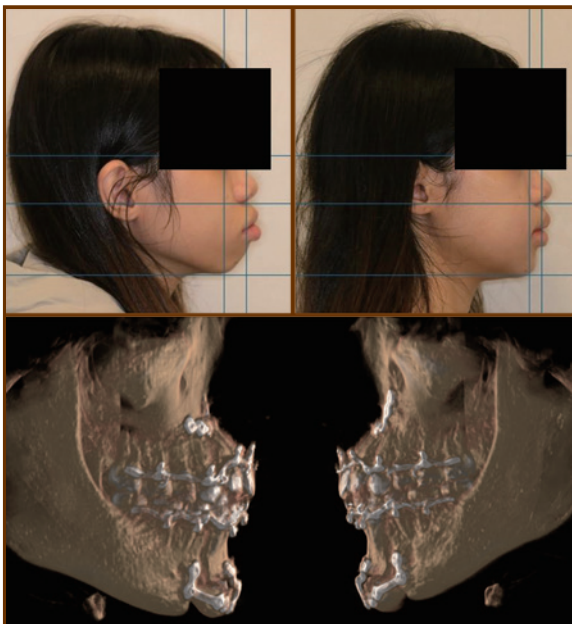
(a) & Fig. 6(b): Post-surgical photos and CT scan showing the protruded jaws have been partially managed by combined surgery of Cupar osteotomy, Hofer osteotomy and advancement genioplasty. Further orthodontic treatment is required to correct the bite (Surgery-first approach). (Clinical images from personal collection) (Orthodontic treatment by Dr Andrew Fu-shan NG, Specialist in Orthodontics; surgery by Dr Eric Ka-fai SIT, Specialist in Oral and Maxillofacial Surgery for the management of a bimaxillary protrusion with anterior dentoalveolar hyperplasia by double-jaw osteotomies)
